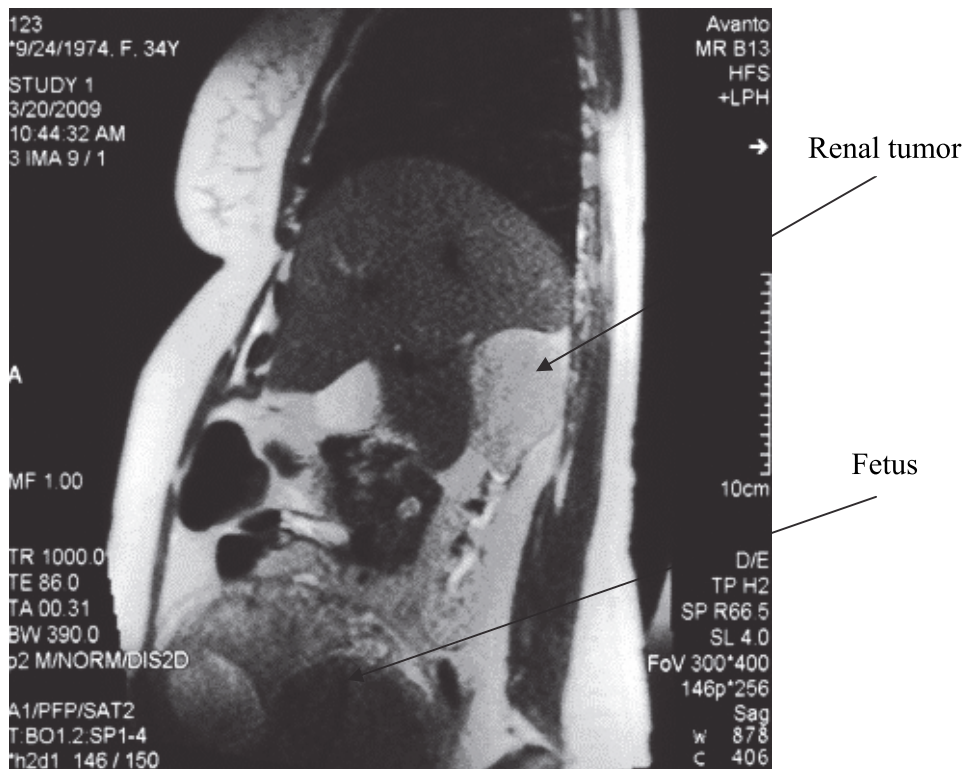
MRI scan demonstrating right renal mass and the fetus
